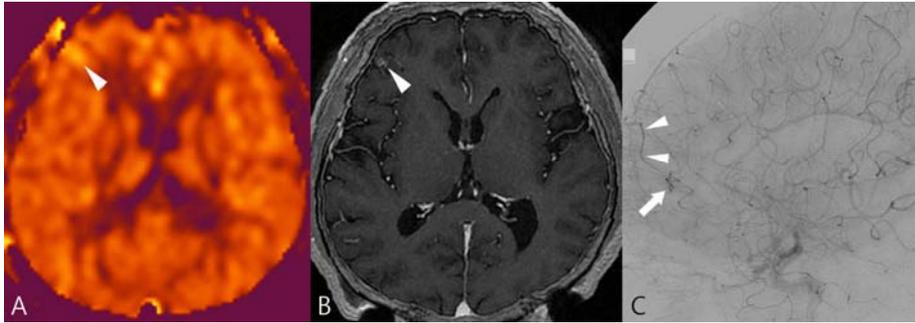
A 54-year-old male who underwent gamma-knife surgery for the right frontal AVM 37 months ago. (A) Axial ASL image shows a slightly high signal intensity in the right frontal lobe (arrowhead). No venosinus signal intensity is clearly demonstrated. Initially, there was disagreement between the reviewers as to whether this intensity corresponded to a nidus. After discussion, the reviewers decided that this asymmetric high signal intensity represented a nidus. (B) Axial T1-weighted post-contrast image shows a small enhancing lesion (arrowhead) in the right frontal lobe. (C) Lateral DSA confirmed a very small nidus (arrow) and cortical vein (arrowheads) draining into the superior sagittal sinus.
